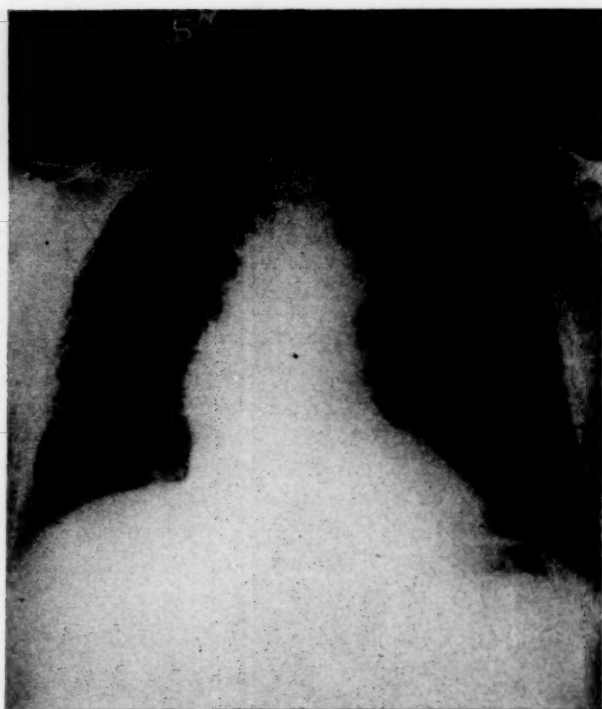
X-ray taken prior to final course of radiation therapy, Case v.
